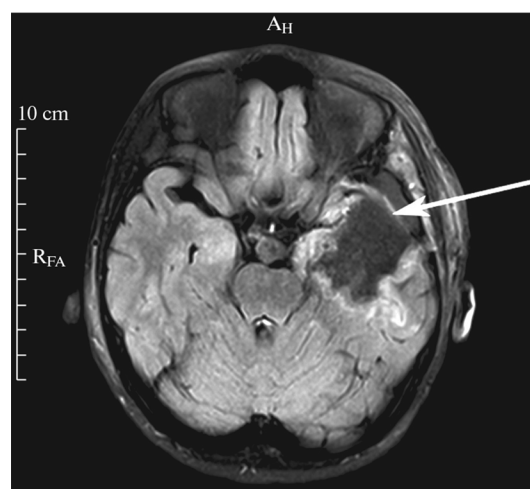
Snapshot of the post-operational MRI for patient 2 following the surgery regarding the post-traumatic refractory epilepsy and type IIIB FCD. The arrow indicates the removed area in the anterior section of the left temporal lobe.
